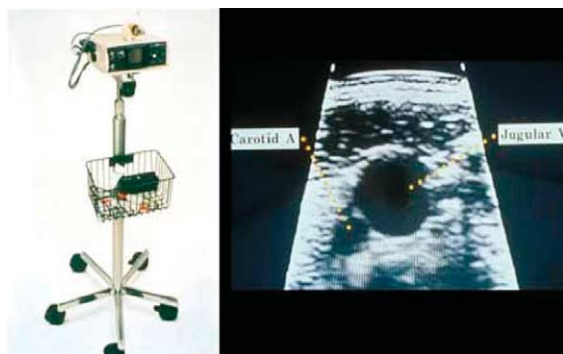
The SITE RITE 3™ is one of the ultrasound devices available, which allows real time visualisation of the internal jugular vein. The images obtained allow clear definition of the internal jugular vein and its relationship to the carotid artery.
